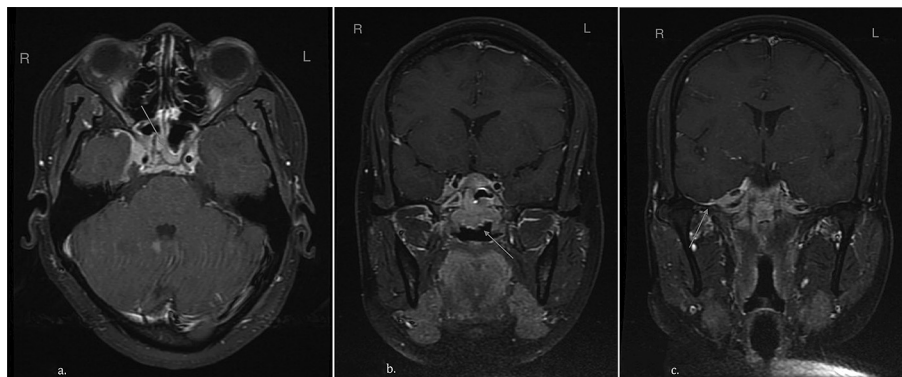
a) MRI head T1 weighted post contrast axial slice. Demonstrating high uptake central skull base lesion at sphenoid sinus (arrow), cavernous sinus with compression of carotid arteries. b) MRI head T1 weighted post contrast coronal slice. A more anterior coronal slice demonstrating mass lesion at cavernous sinus, sphenoid sinus and extension into nasopharynx (arrow). c) MRI head T1 weighted post contrast coronal slice. A more posterior coronal slice demonstrating extension of mass into the right middle cranial fossa (arrow).
